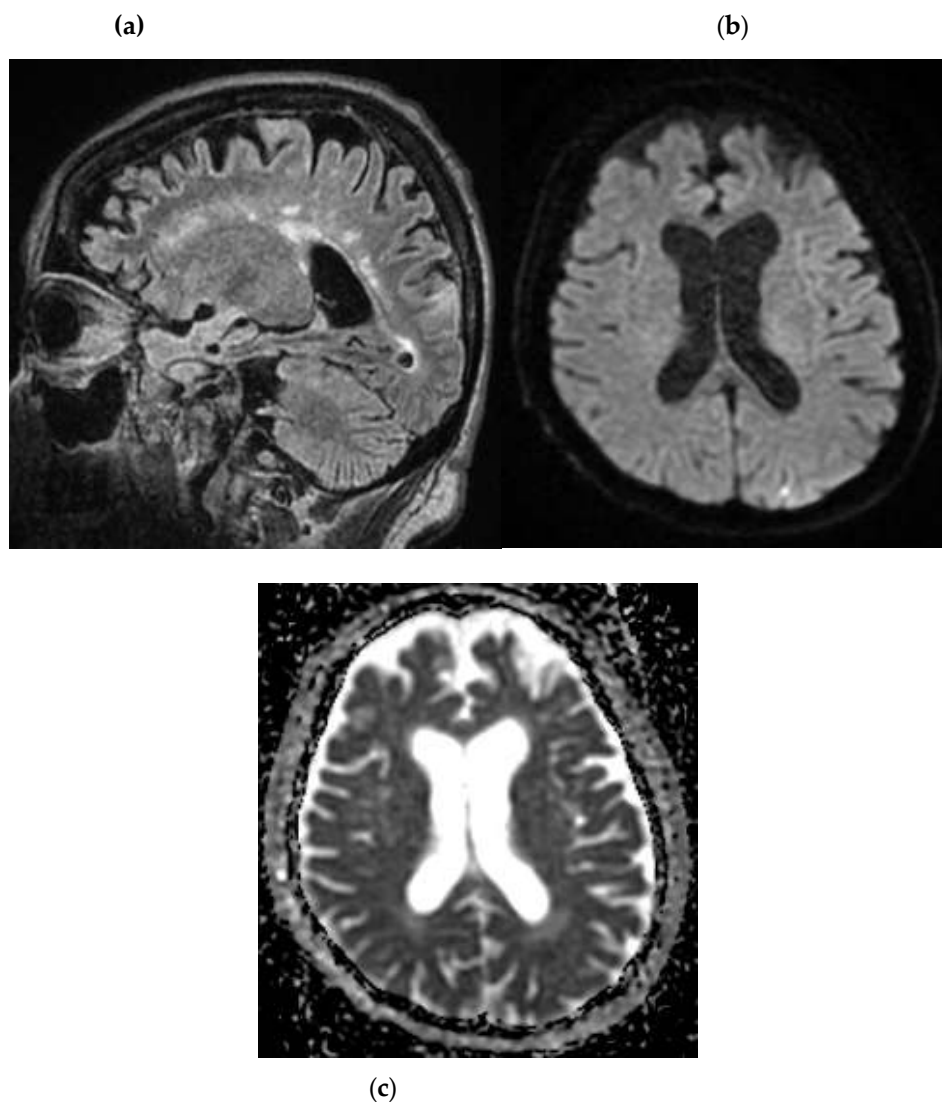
MRI sequences for the Case 8 patient indicate infra-centimetric foreshore of intense FLAIR signal (a), moderately restrictive in diffusion (b,c), situated on the left superior occipital lobe revealing subacute left superior occipital infarction.
